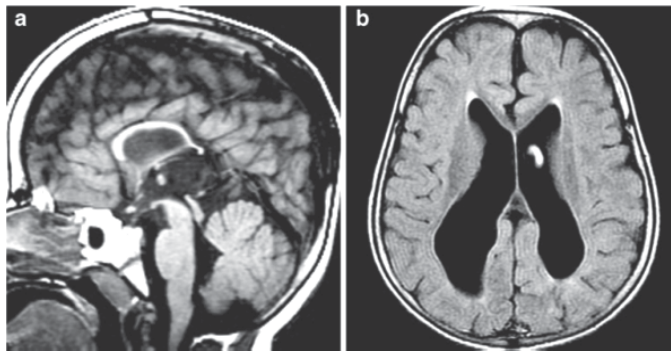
Diffusely hypoplastic commissural plate with ventriculomegaly, Midline (a) sagittal T1WI. The commissural plate is complete but thin with a tiny splenium, Axial FLAIR (b). Diffuse ventriculomegaly without real evidence of leukomalacia: this points to a global white matter disorder that may be developmental or acquired, not a commissural disorder (Raybaud, 2010).
